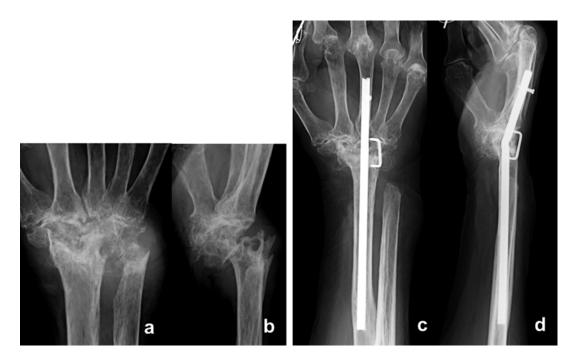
Total wrist fusion using a new intramedullary rod, WFR. (a, b) Preoperative radiograph. (c, d) Postoperative radiograph
